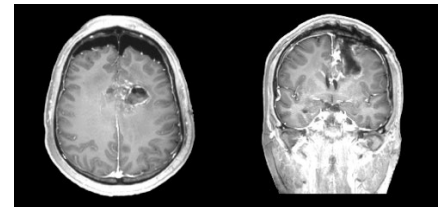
Post-operative MRI - Day 1.
